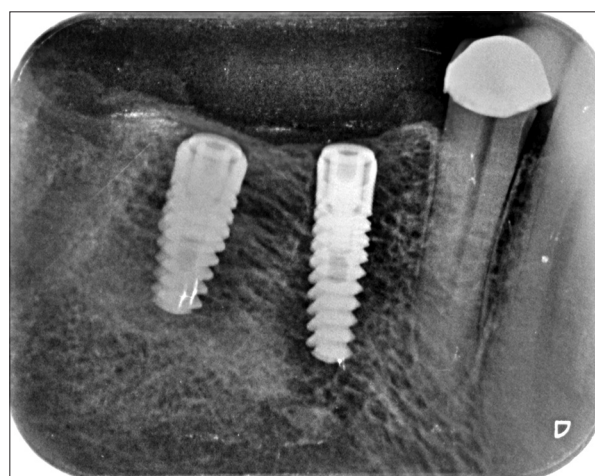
The digital intra-oral periapical image of Case no 5 taken after implant insertion showing two implants in 45, 46 sites
